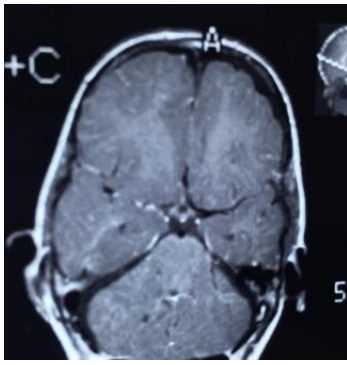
post op.T1 Brain MRI with contrast
